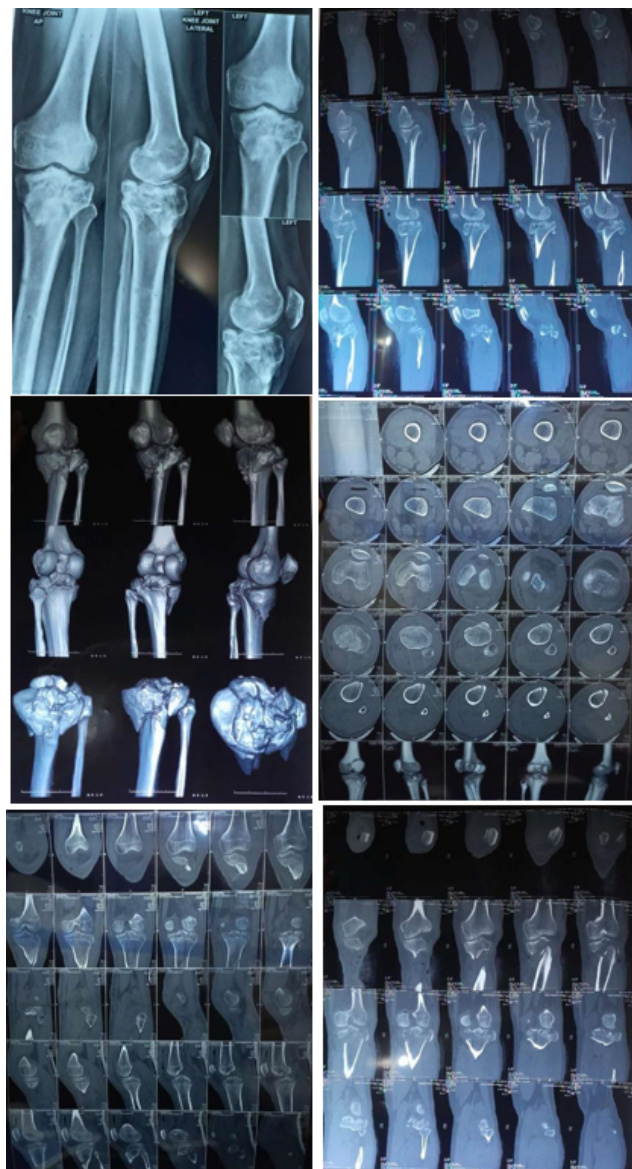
Case 1: Preop x-ray and CT scan
